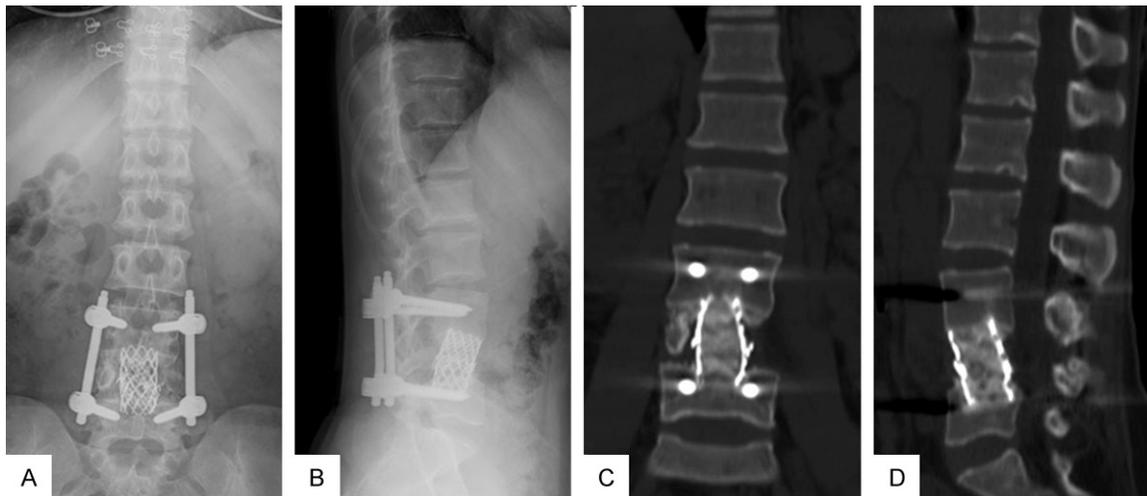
X-rays (A, B), mid-coronary (C) and mid-sagittal CT images (D) demonstrate TMC fracture and collapse.
